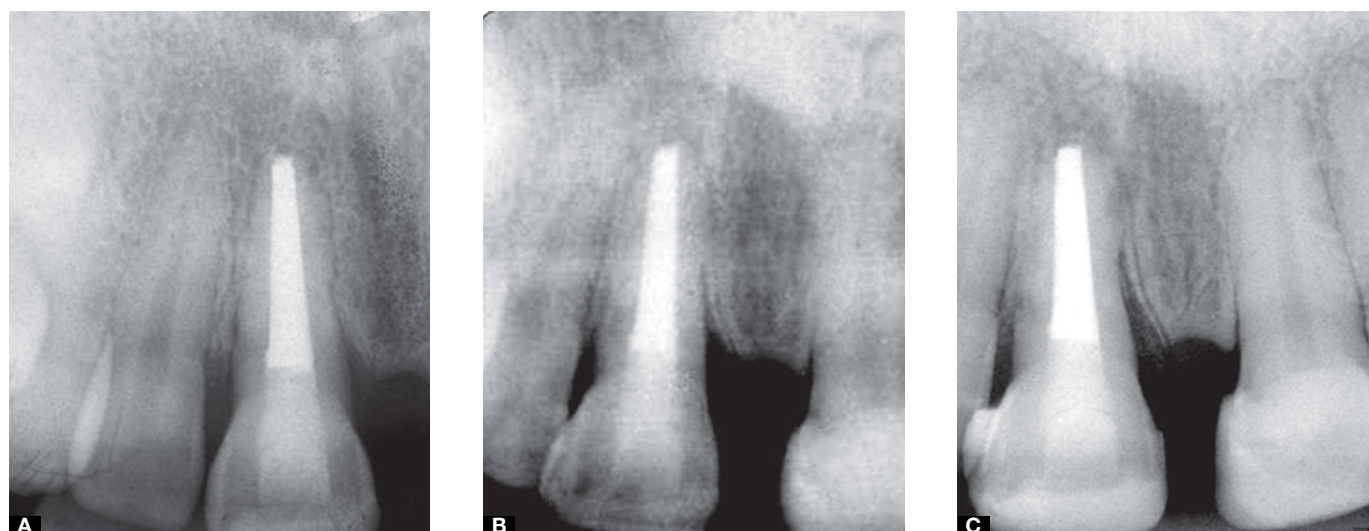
Periapical radiographs of the upper right central incisor. A) Radiographic exam at the eighth appointment, at the end of the obturation by the lateral condensation and Sealapex. B) Radiographic exam for 6-month postoperative control; note the total remission of the lesion and apical closure. C) Radiographic exam for 18-month postoperative control; note the total remission of the lesion and apical closure.
